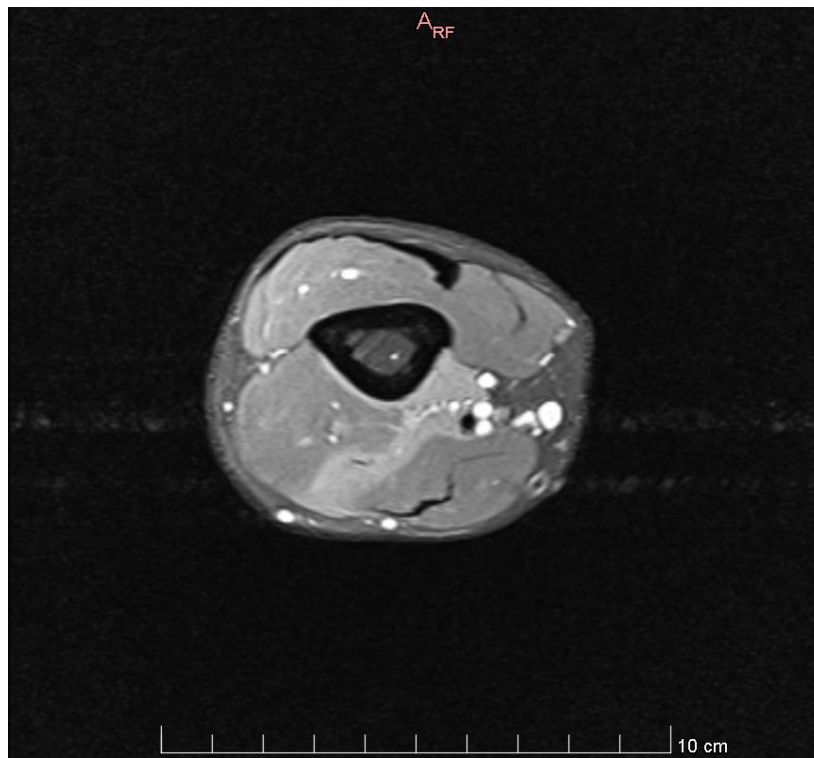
Edema of the brachial muscle, reduction of its volume and beginning of fat infiltration - transverse-section (Source: MRI of right elbow joint 05.08.2022)
